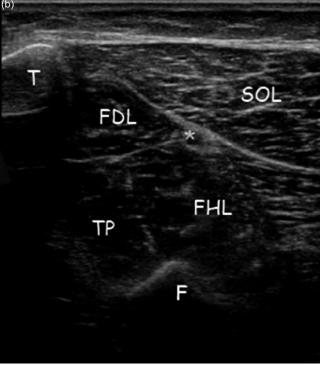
Flexion of the toes. (a) The flexor hallucis longus and flexor digitorum longus muscles. (b) Transverse ultrasound image of the left calf showing the flexor digitorum longus (FDL) and flexor hallucis longus (FHL) muscles and the tibialis posterior (TP); T near tibia; F near fibula; SOL, soleus; asterisk, neurovascular bundle. (c) Probe and injection for the flexor digitorum longus muscle. (d) Probe and injection for the flexor hallucis longus muscle.
